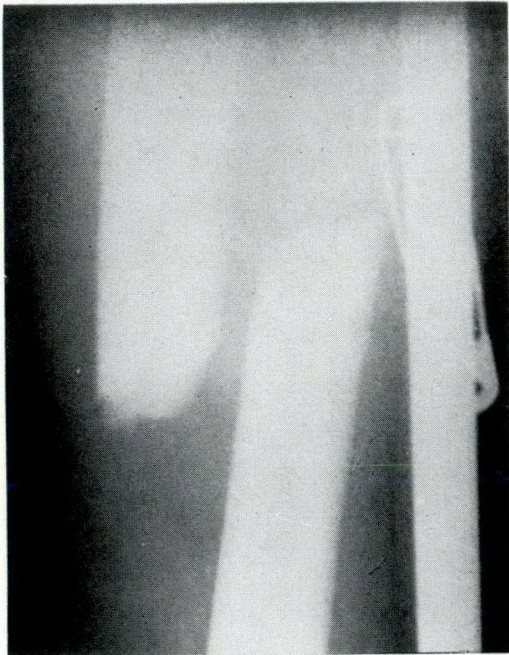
Case 5. On the basis of this radiograph, treatment was undertaken.
